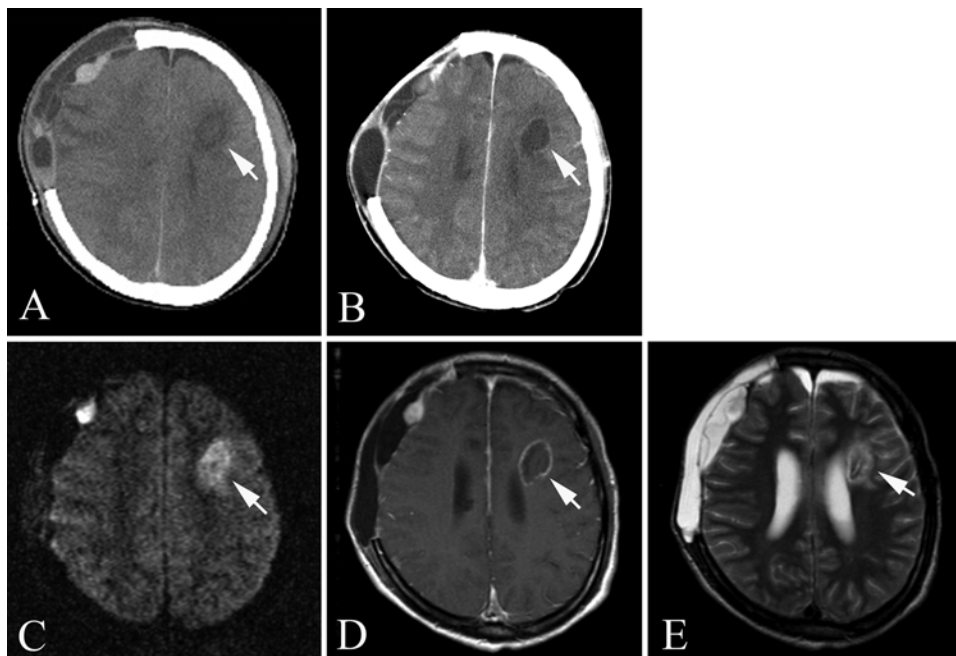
A: Axial CT image obtained on Day 10 demonstrating that the low-density area in the left frontal lobe parenchyma (*white arrow*), in the previous location of the ICP transducer, is slightly more conspicuous than on Day 5. B: Contrast-enhanced CT image obtained on Day 27 demonstrating a reduction in the low-density area (*white arrow*) compared with Day 10. C–E: Axial MR images obtained on Day 28, including diffusion-weighted (C), Gd-enhanced T1-weighted (D), and T2-weighted (E) sequences. The diffusion-weighted and T2-weighted images demonstrate a high-intensity lesion with a low-intensity center approximately 26.5 mm in diameter (*white arrow*), which is a well-circumscribed ovoid mass deep in the white matter of the left frontal lobe near the frontal angle of the left lateral ventricle, in the previous location of the ICP transducer. The T2-weighted image also demonstrates a high-intensity tract inside a low-intensity center surrounded by a small high-intensity area. The high-intensity tract corresponds to the shape and location of the tip of the ICP transducer. The Gd-enhanced T1-weighted MR image reveals a ring-enhancing lesion (*white arrow*). The ring enhancement in the Gd-enhanced T1-weighted image (D) corresponds to the small area of high signal intensity surrounding the lesion in the T2-weighted image (E).
